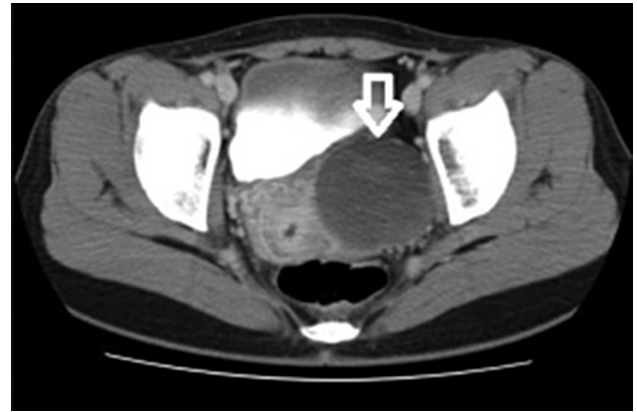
Contrast-enhanced computed tomography indicated a round mass in the left anterior pelvic cavity.
